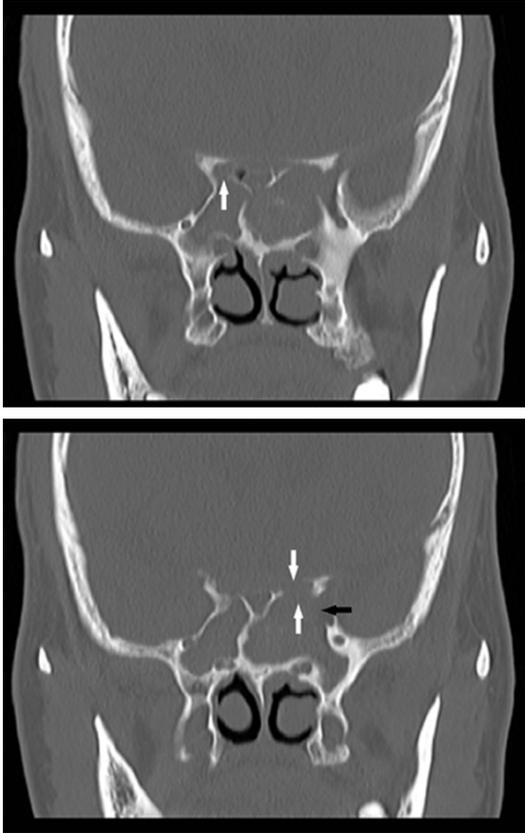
Preoperatively, coronal computed tomography of the paranasal sinuses revealed opacified sphenoid sinuses with intralesional hyperdensity and bony wall defects at the optic canals on both sides (white arrows) and the lateral wall of the left sphenoid sinus (black arrow).
